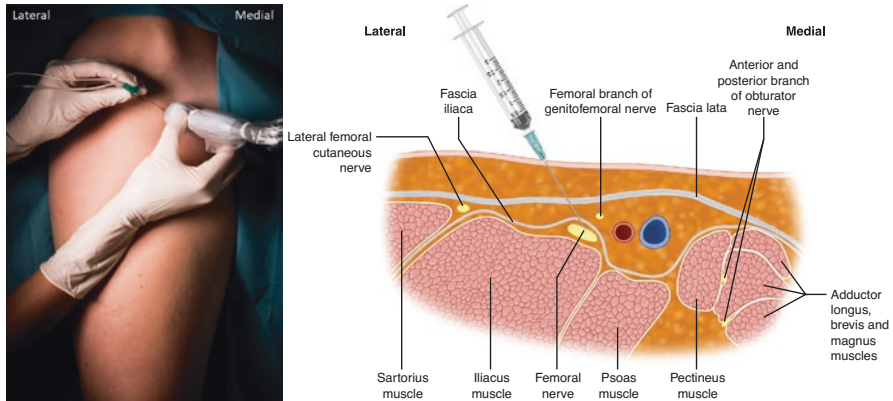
Femoral Nerve Block ultrasonogram
